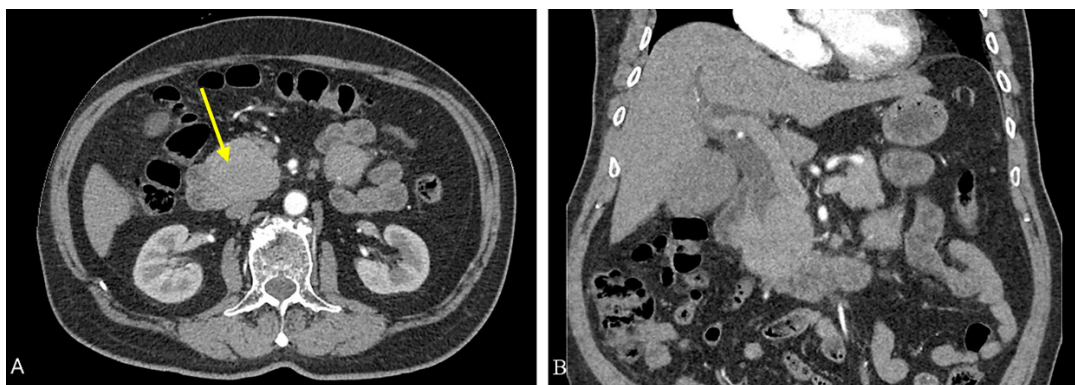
(A) Computed tomography (CT) scan revealed an ill-defined lobulated soft tissue lesion at the head/uncinate process of the pancreas measuring 4.5 cm x 4.9 cm x 5.8 cm. The mass is isodense to the rest of the pancreas in the portovenous phase. There is no clear fat plane with the D2 of the duodenum laterally (arrow). (B) Dilatation of common bile duct and intrahepatic ducts are evident.
